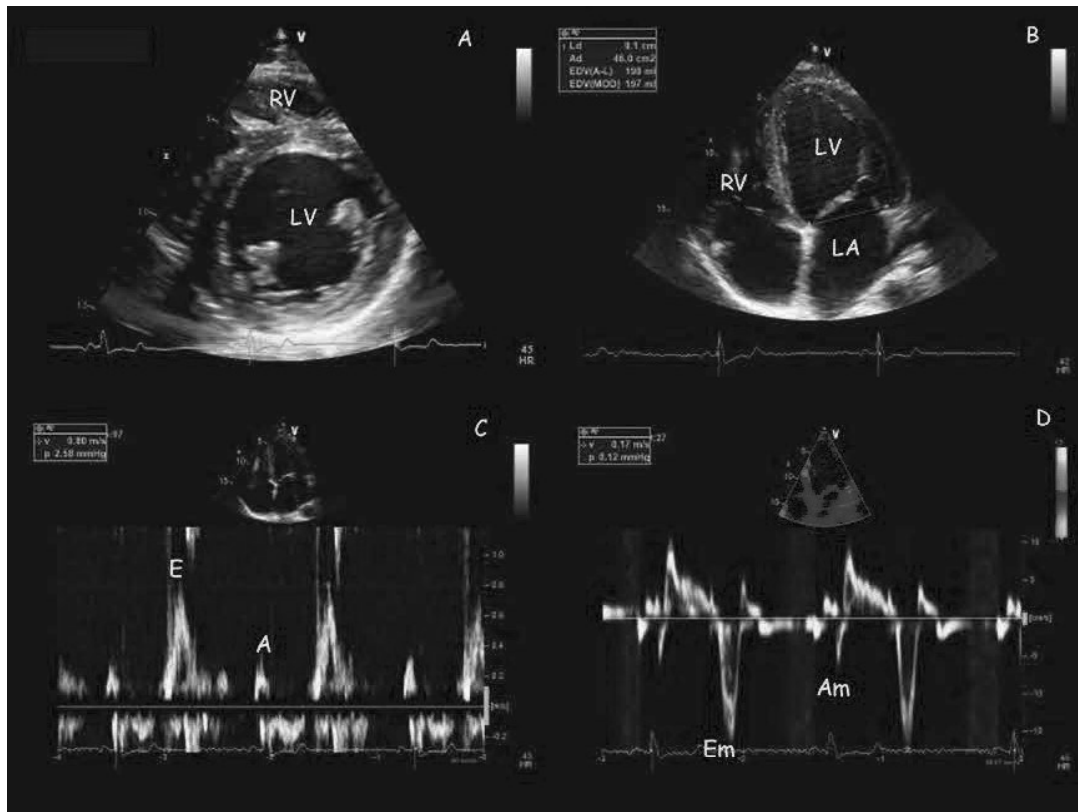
Standard echocardiography and tissue Doppler of an endurance athlete. Note the symmetric increase in both LV and RV cavity diameters (A) and volumes (B) and also the LA consensual dilatation. LV diastolic function, despite the LV hypertrophy, is “supernormal,” with main increase in the early-diastolic relaxation both at global (C) and regional (D) levels. *RV*, right ventricle; *LV*, left ventricle; *LA*, left atrium.
